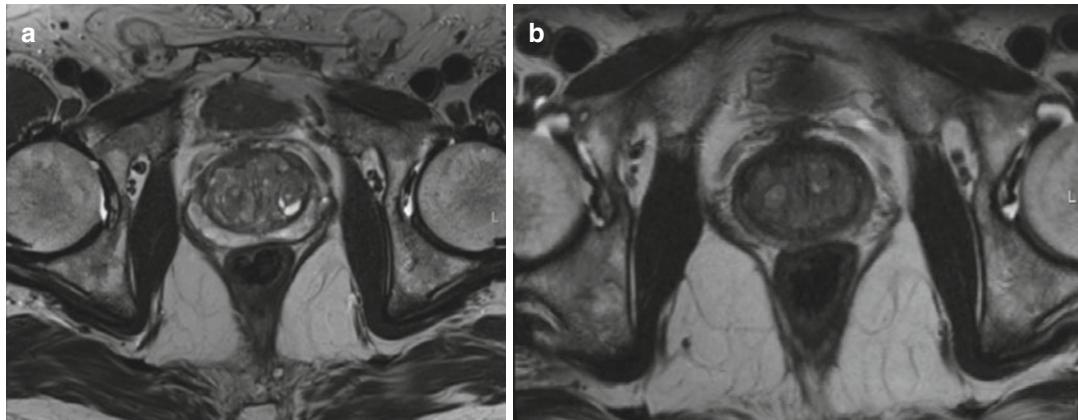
Effect of hormonal treatment on the prostate. Axial T2-weighted images (a) before and (b) after treatment with hormone shows the less clarity between the zonal anatomical regions within the prostate
